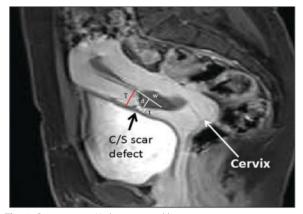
Cesarean scar Niche measured by magnetic resonance imaging: D stands for the defect's depth, w for its width, t for the scar myometrium's thickness, and T for the adjacent myometrial thickness [26]
